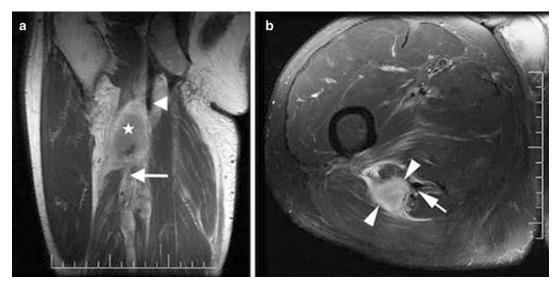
Coronal and axial fat-suppressed MRI of the thigh. The coronal MRI (a) depicts an avulsion of the biceps femoris and semitendinosus muscles with a large hematoma (*star*) and the retracted fibers of the long head of the biceps (*arrows*). The axial MRI (b) shows a
